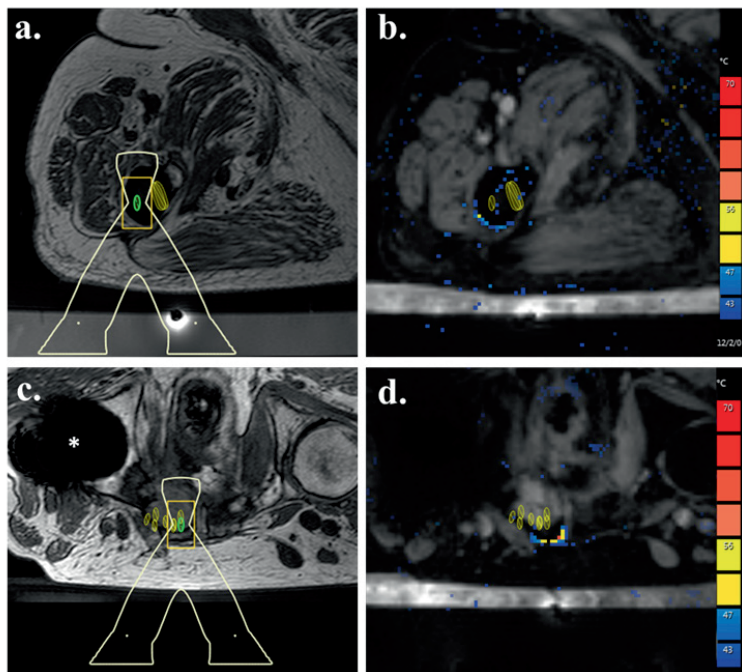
Images acquired during the treatment session of two patients with osteoblastic metastasis in femur (first row) and osteolytic metastasis in pelvis (second row), this patient had also an implant in the right femur, indicated by *. In both cases, the metastases were surrounded by fat and bone. (a.-c.) Images from the planning sequence, with the location of the planned sonications (in green) and the shape of the ultrasound beam cone overlaid. (b.-d.) the MR thermometry maps, estimated with the PRFS method: temperature estimates could only be calculated in the soft tissues in the proximity of the lesions.
